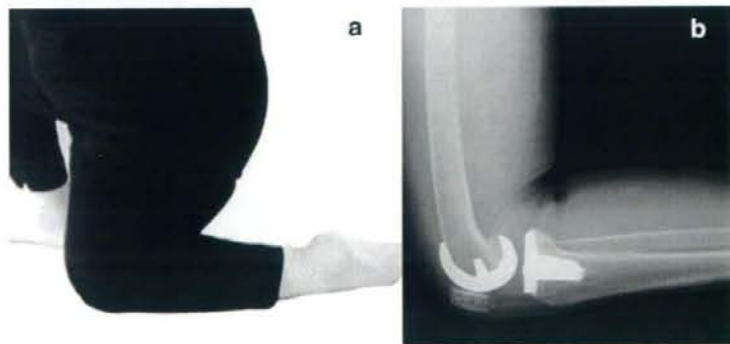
Each subject was asked to perform kneeling from 90° to maximum knee flexion (a). Continuous X-ray images of kneeling were taken using a flat panel detector (b).
